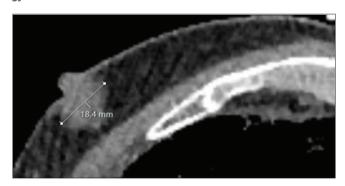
Computed tomography images showing vertical growth of glandular tissue density with an axial diameter of 1–2 cm
